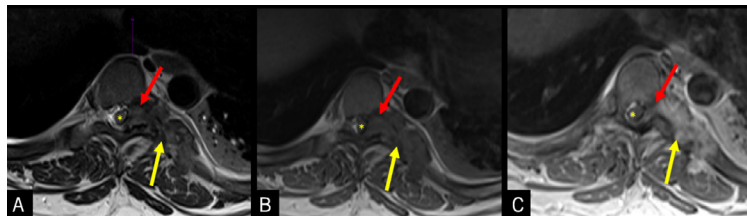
Axial MRI images of the thoracic spine demonstrate multiple paraspinal T2 hypointense (A) and T1 hypointense (B) masses with post contrast enhancement (C) (yellow arrows). The mass is noted to involve the posterior thoracic spinal elements, paraspinal soft tissues, and intercostal space. Some of these masses are noted to extend through the neural foramina into the epidural space (red arrows) with associated compression of the spinal cord (asterisk).
